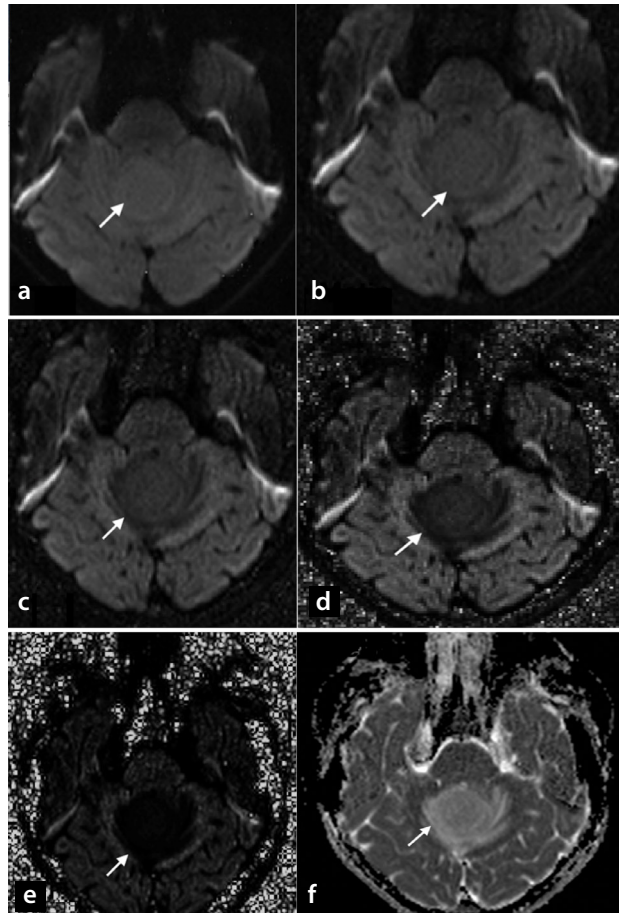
A 15-year-old female with juvenile pilocytic astrocytoma. (a) Diffusion-weighted imaging (DWI)₁₀₀₀, (b) computed DWI (cDWI)₁₅₀₀, (c) cDWI₂₀₀₀, (d) cDWI₃₀₀₀, (e) cDWI₅₀₀₀, and (f) apparent diffusion coefficient (ADC)₁₀₀₀ maps. In the mass located in the 4th ventricle, indicated by the arrow, on DWI with increased b-values, the signal loss of the tumor tissue is more prominent than that of the parenchyma. In addition, a high signal is observed in the parenchyma in the ADC₁₀₀₀ maps (f).
